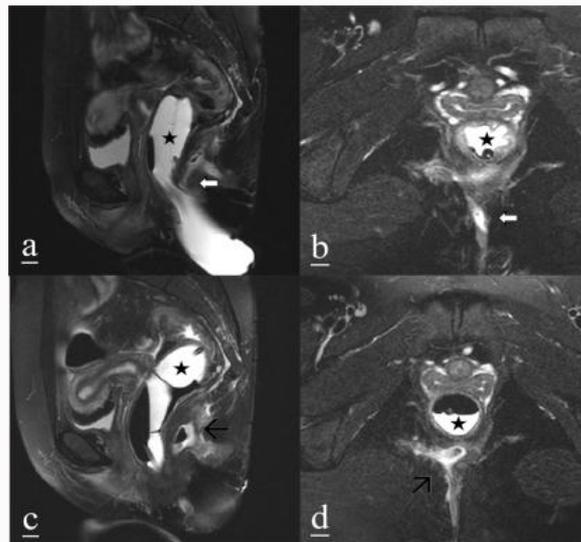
A 32-year-old woman with perennial fistulizing CD achieved clinical remission at the 48-month follow-up. A, b: Preoperative MRI showing a Suprasphincteric fistula in the deep postanal space (white arrows); c, d: Follow-up MRI showing the internal orifice of the anal fistula closed by fibrous tissue; the fistula in the deep space behind the anal canal is replaced by a fibrous scar; a closed sinus tract is seen in the intersphincteric space (black arrow). ★-A water sac placed in the rectal cavity.
